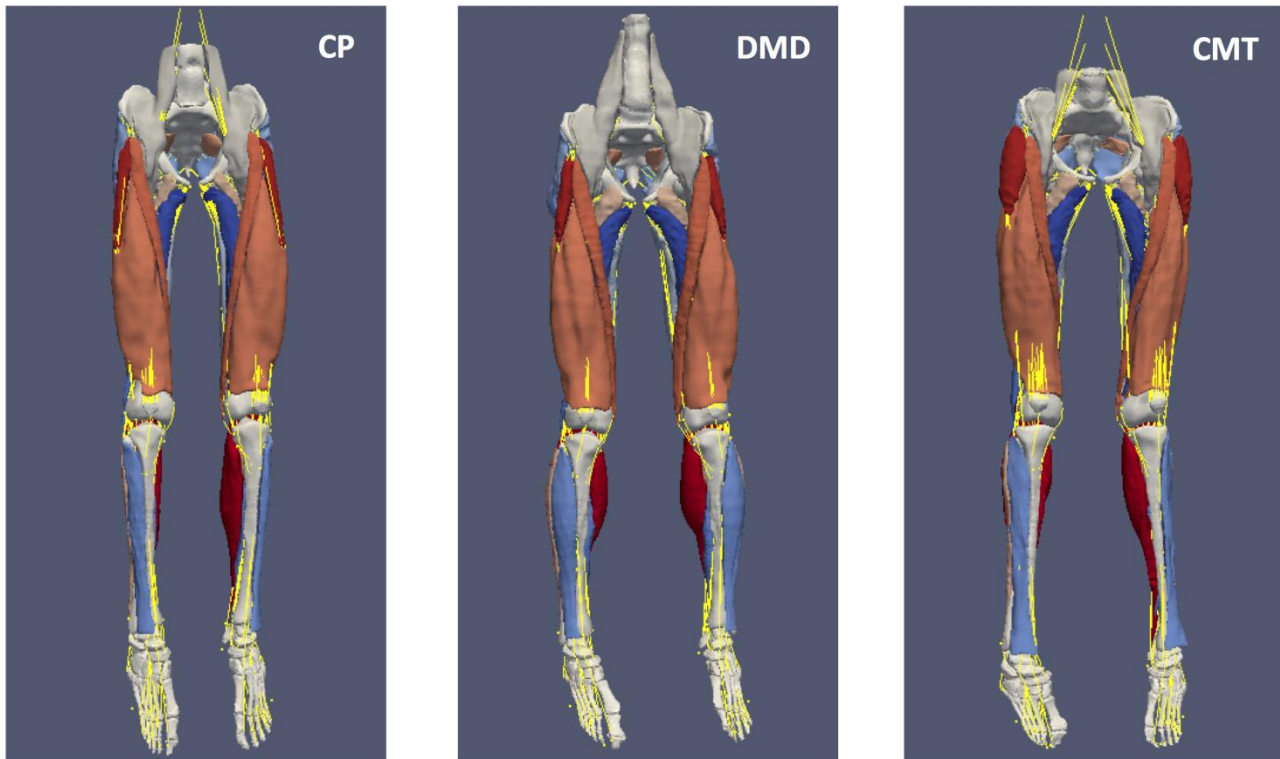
Three examples of patient-specific complete anatomical model, one for each of the diseases (CP, DMD, and CMT). They have been obtained by the morphing of the template anatomical model to the geometries segmented from MRI. Detailed visual assessment was performed for all the cases.
